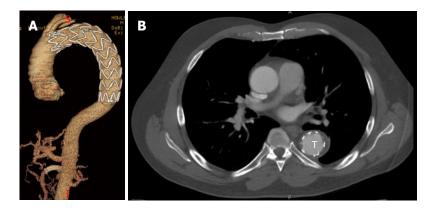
Remodeling after thoracic endovascular aortic repair. A: Follow-up 3D reconstruction from a computed tomography angiography of a patient who underwent TEVAR with adjunct superior mesenteric artery stenting for acute type B aortic dissection with malperfusion. There no evidence of endoleak or aneurysmal degeneration; B: Axial sections from same patient highlighting T expansion with evidence of false lumen thrombosis. TEVAR: Thoracic endovascular aortic repair; True lumen
